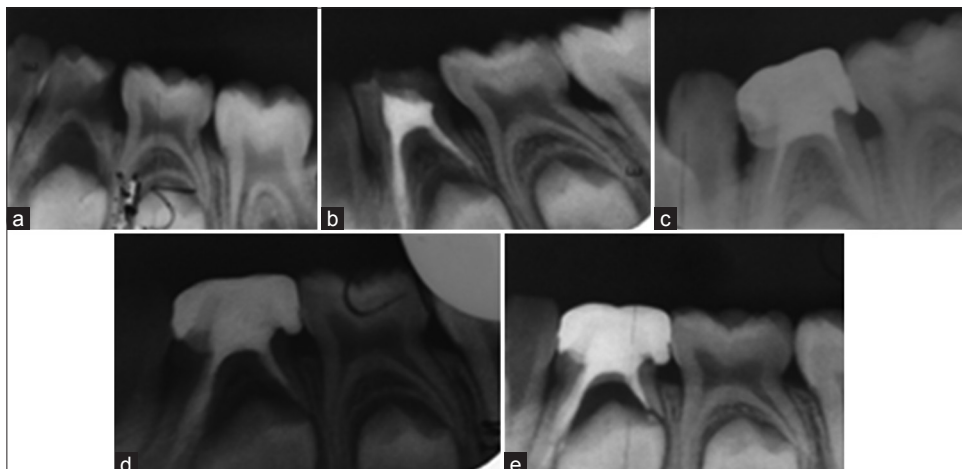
75 treated with vitapex as obturating material after pulpectomy (radiographic success) (a) Preoperative (b)postoperative (c) After 6 months (d) after 12 months (e) After 18 months
